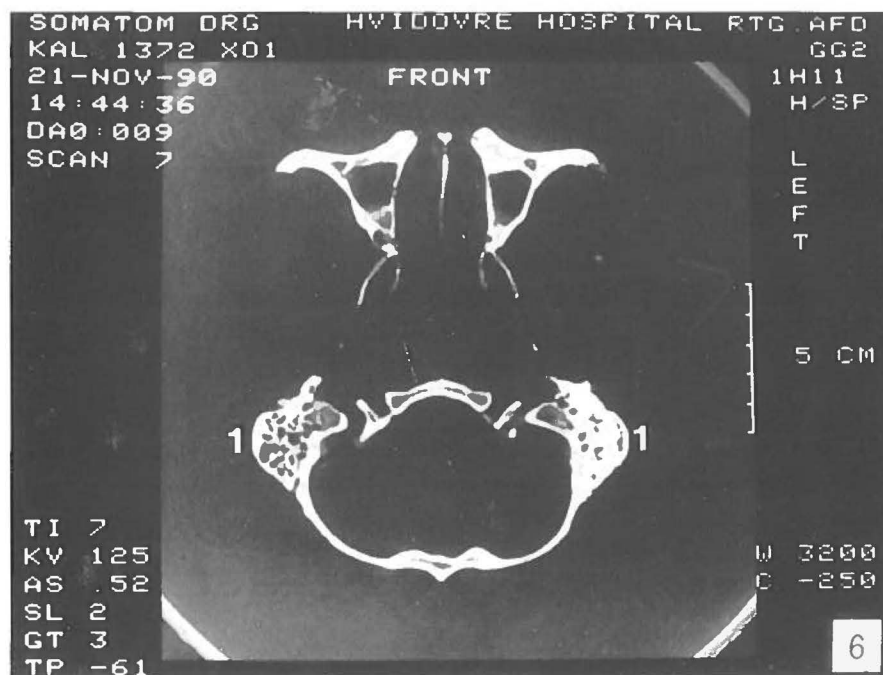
CT-scan at the mastoid level (1) of cranium no. 4. The left side displays sclerosing and irregularity.
